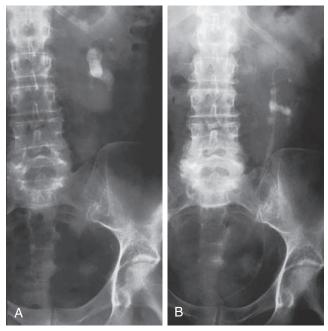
Extracorporeal shock wave lithotripsy (ESWL) complicated by Steinstrasse. (A) Preoperative plain radiograph showing stones in the left renal pelvis. (B) After ESWL, note the disappearance of the pelvic stone, the string of stone fragments throughout the length of the ureter, and the double-J ureteral stent placed to facilitate their passage.
